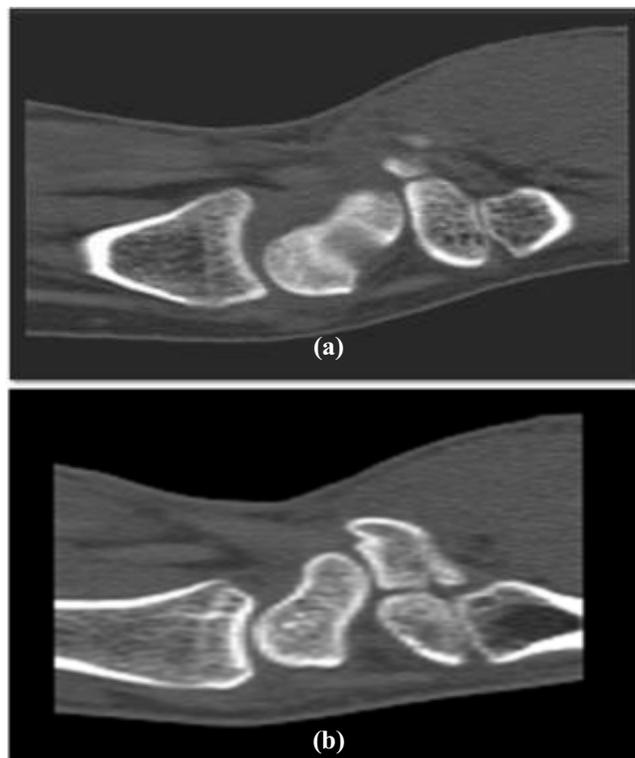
Computed tomographs selected for measurement. a-sections in which the capitata head (C) could be observed between the proximal (PP) and distal (DP) poles of the scaphoid were used to determine the position of the capitata head relative to the scaphoid. b-sections with the complete scaphoid (S) were used to measure scaphoid dimensions;
